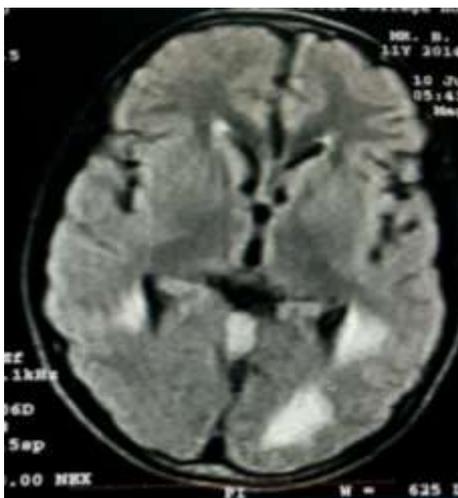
Coronal MR imaging showing hyperintense lesions in white matter of both temporal lobes and left occipital lobe suggestive of demyelination
